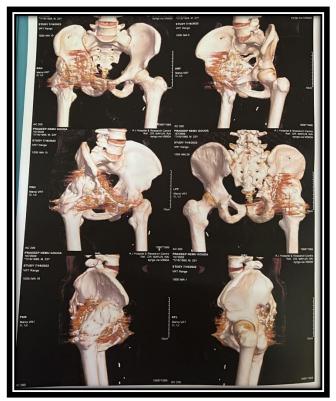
Depecting 3D reconstructed CT of Right Hip with Heterotopic Ossification
